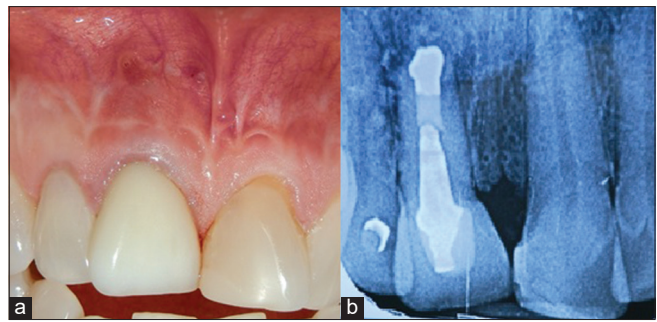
Clinical view. (a) Condition of the gingiva and oral mucous in tooth number 8. Swelling, redness, scar, and vestibular fistulae in the apical zone of the tooth. (b) Periapical X-ray showing a previously apical surgery with retro-obturation in amalgam of silver
